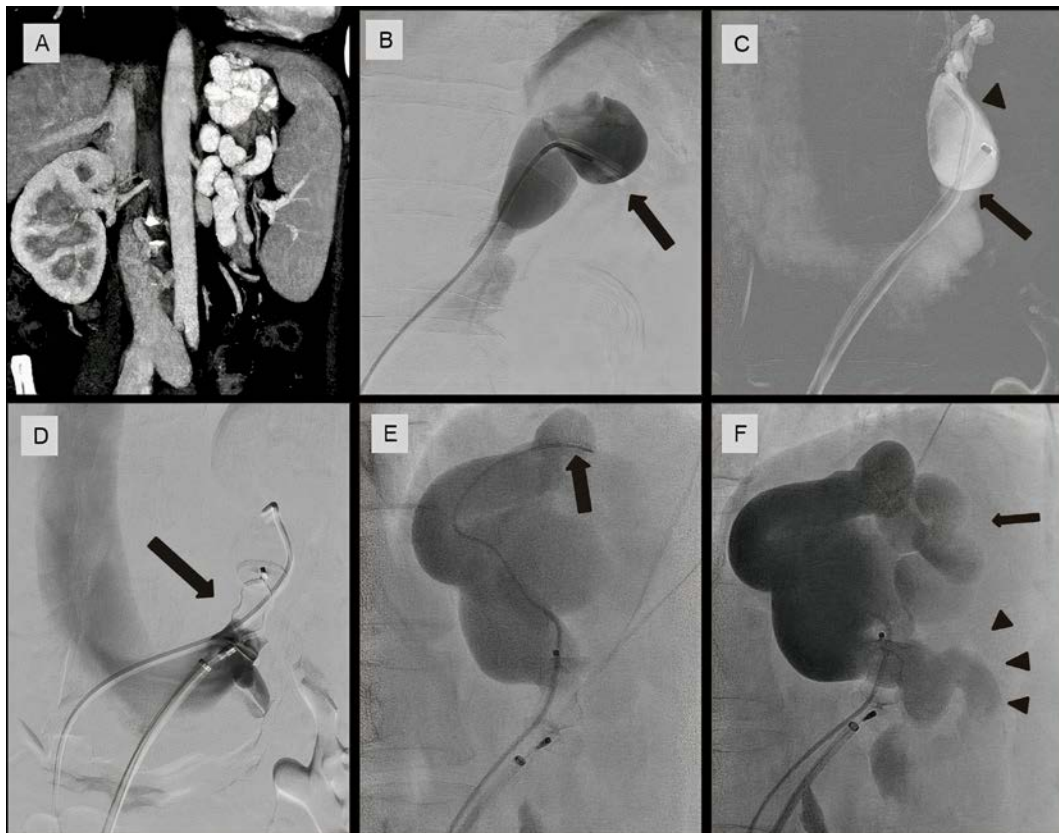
A. Post contrast CT coronal section showing isolated gastric varices with splenomegaly (left-sided portal hypertension).
